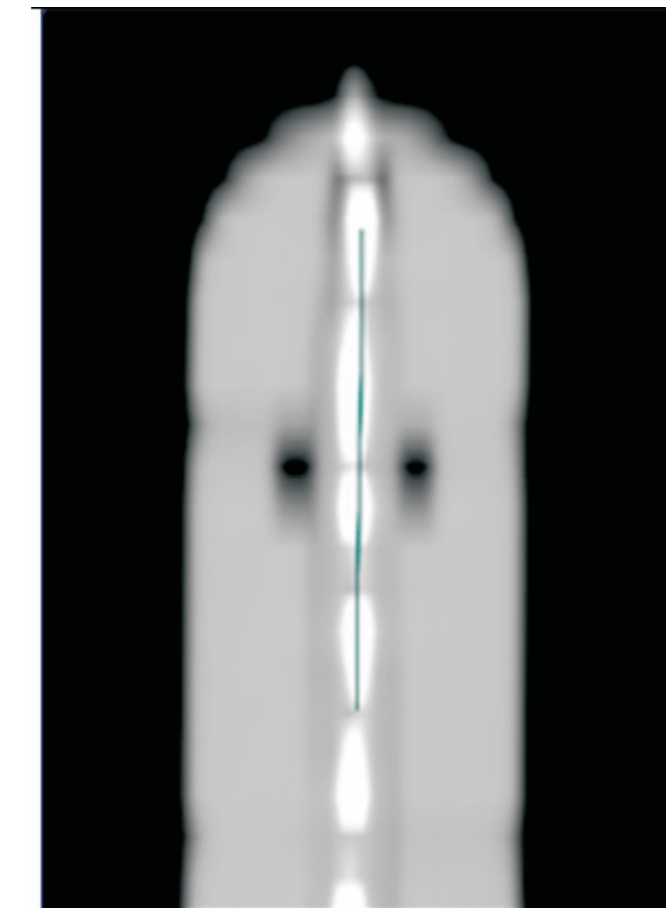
Deep ogive's digitally reconstructed radiography.
